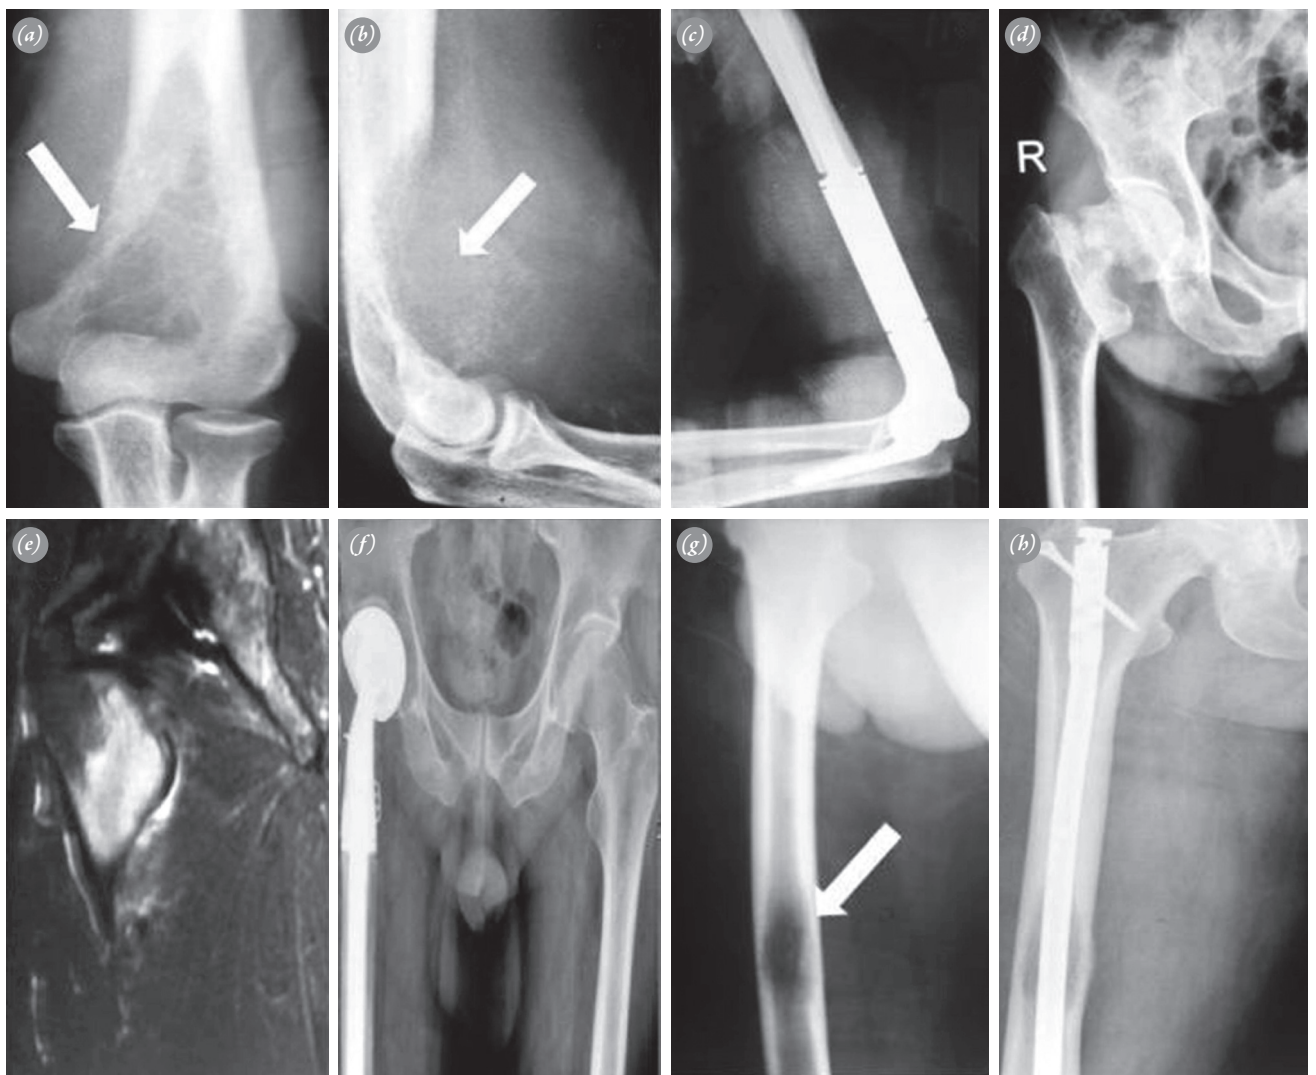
(a) AP and (b) lateral radiograph of a single metastasis of renal carcinoma to the distal humerus; (c) Postoperative X-ray showing the endoprosthetic replacement of the distal humerus; (d) Osteoblastic metastasis of the right proximal femur, showing a pathological fracture on AP radio-graph; (e) MRI image; (f) Postoperative X-ray of endoprosthetic replacement of the proximal femur; (g) Lytic skeletal metastases of bladder cancer of the right femoral diaphysis on AP X-ray; (h) Patient treated with an unreamed interlocking nail.
